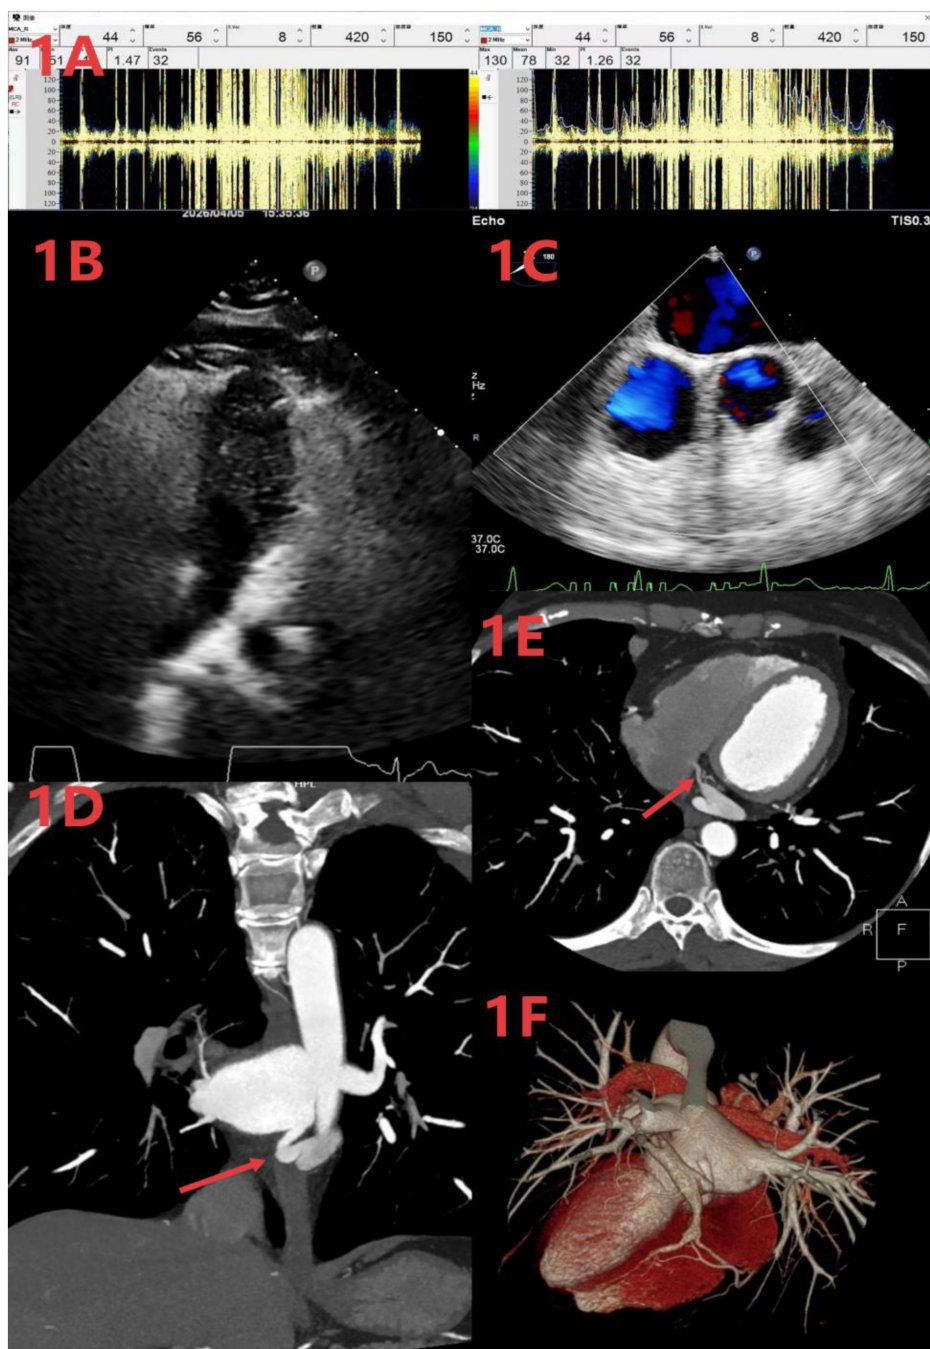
Multimodal imaging of isolated coronary sinus atresia. A: Transcranial Doppler bubble test (positive right-to-left shunt); B: Transthoracic contrast echocardiography: Abundant microbubbles (>30 per frame) in left atrium and left ventricle, indicating grade 3 right-to-left shunt; C: Color Doppler (no interatrial shunt); D: Coronal computed tomography (CT) (atretic coronary sinus ostium, arrow); E: Axial CT (great cardiac vein-left atrial branch, arrow); F: 3D CT reconstruction.
